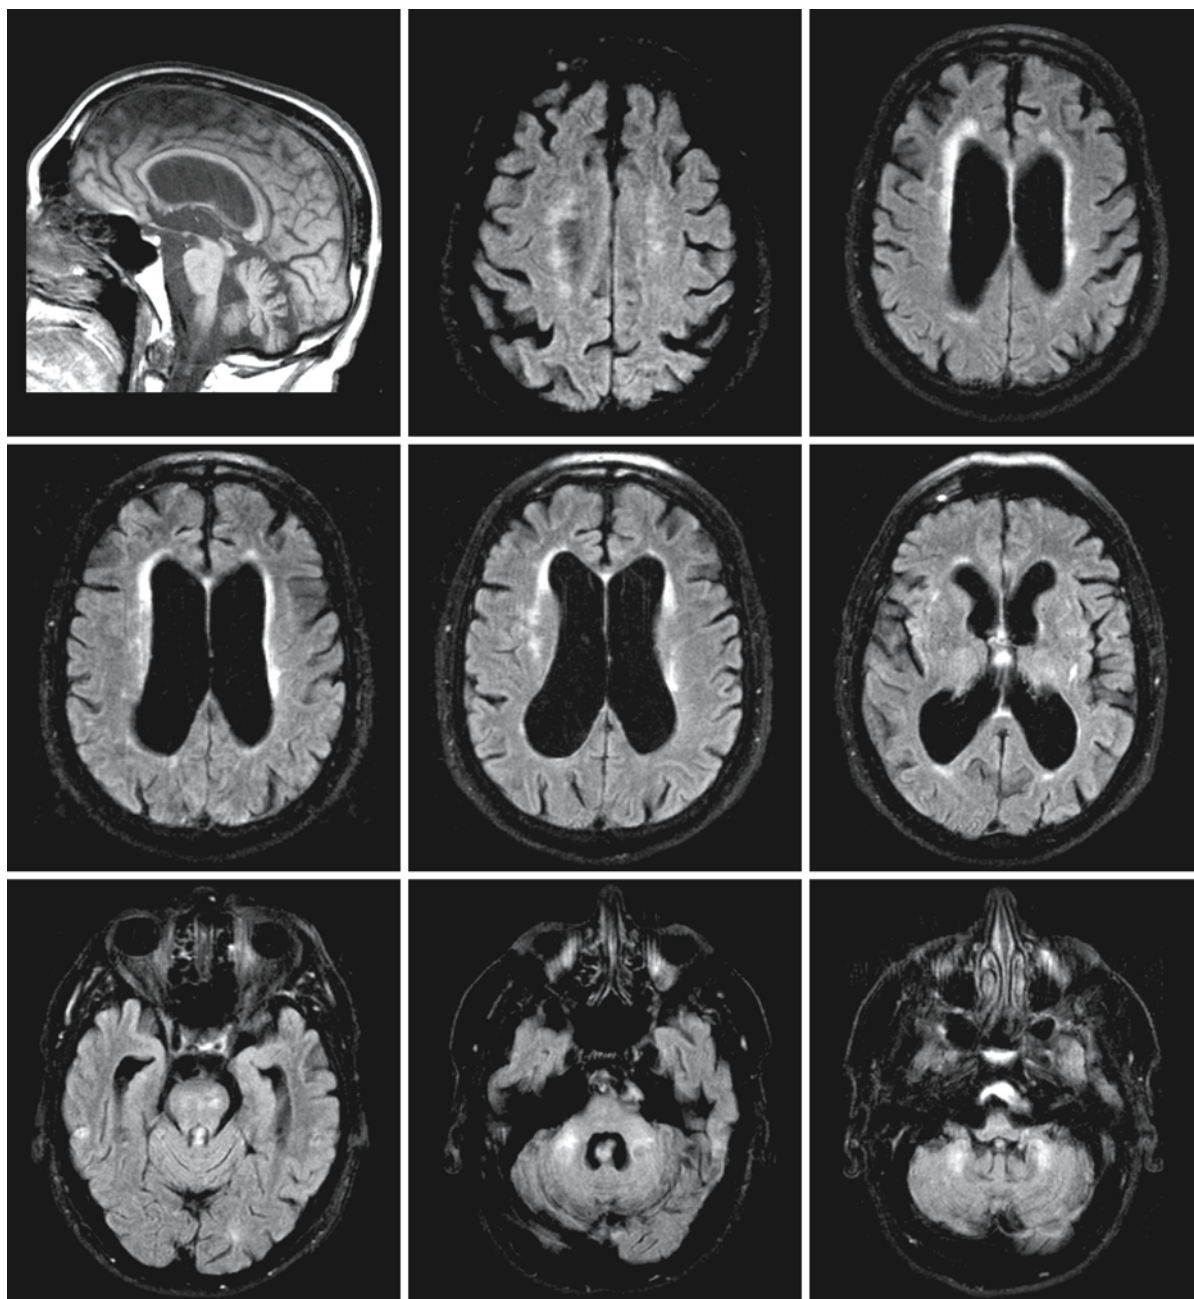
A 63-year-old man with a fragile X premutation. A CGG repeat with a length of 90 trinucleotide repeats was demonstrated in the *FMR1* gen. These sagittal T₁-weighted image (first row, left) and axial FLAIR images show prominent cerebral and cerebellar atrophy. There is a periventricular rim
